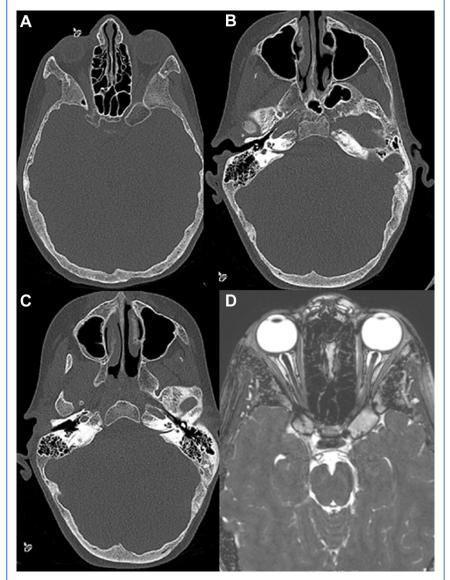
(A) Head computed tomography showing diffuse thickening of the calvaria, facial bones, and spinous processes of the upper cervical vertebrae, abnormal vertical orientation of the clivus, foramen magnum stenosis, severe narrowing of the bilateral optic canals with thickening of the anterior clinoid process, and narrowing of the right (B) and left (C) internal auditory canals (D). Brain magnetic resonance imaging T2-weighted imaging bilateral optic canal stenosis shows a smaller edematous right optic nerve compared with the left.
